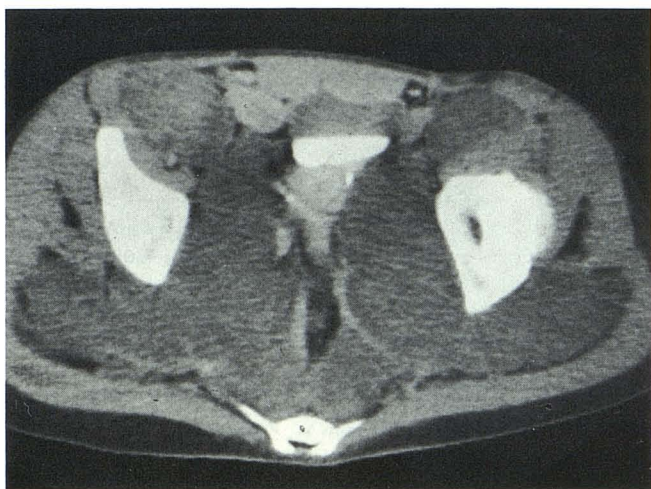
Case 1: neurofibromatosis and bilateral leg pain and weakness. CT demonstrates bilateral, large, low-attenuation pelvic masses extending through GSF. Surgical biopsy revealed these to represent bilateral liposarcomas.
